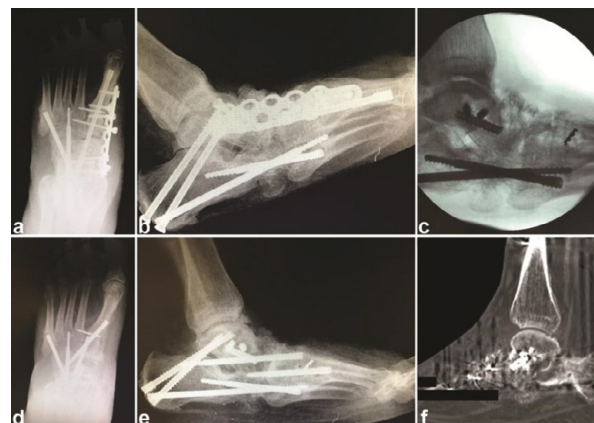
Case #5, a 65-year-old male who had undergone medial column fusion of the right foot for Charcot reconstruction two years earlier and presented with nonunion of the talonavicular joint. (A) Preoperative anteroposterior and (B) lateral radiographs. The patient required revision arthrodesis with new hardware and rhPDGF-BB/β-TCP. At 15 weeks postoperative, anteroposterior (C) and lateral (D) radiographs demonstrated joint fusion, which was confirmed by CT scans (E, F).
